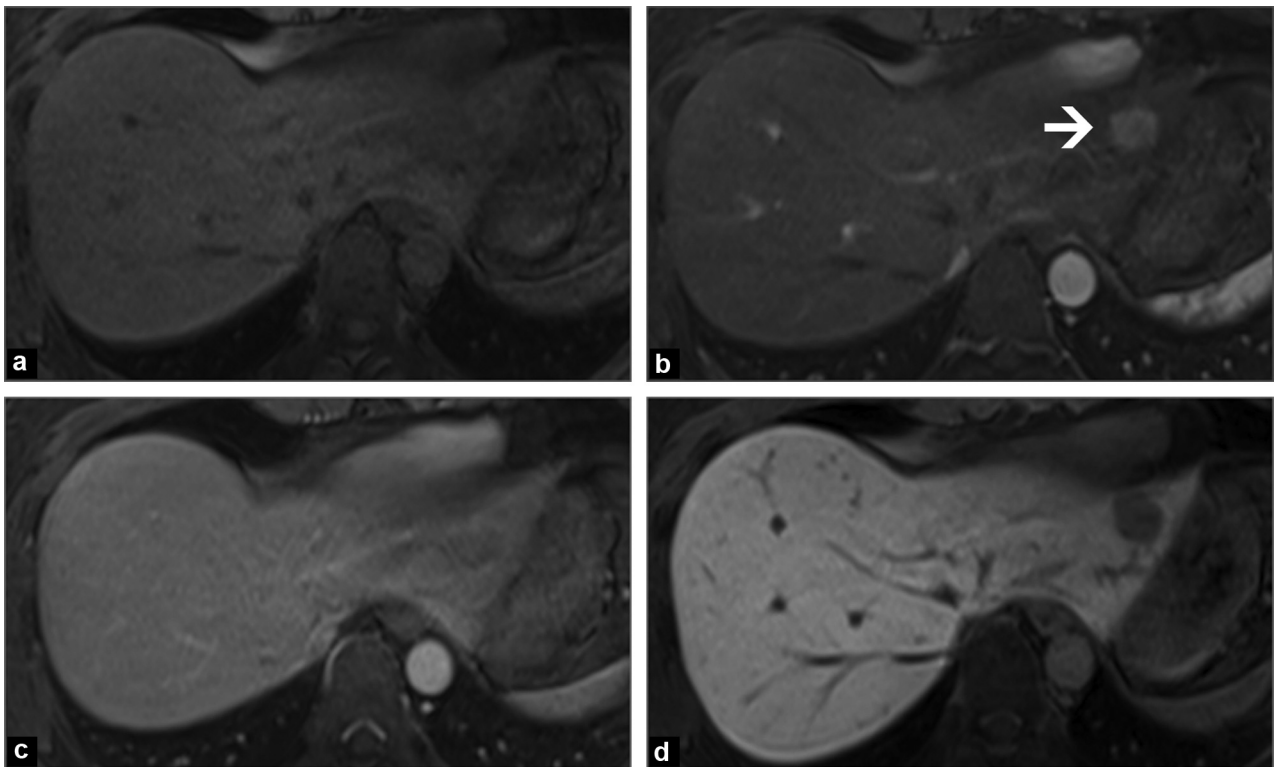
The usefulness of liver-specific contrast agents. T1-weighted MRI without (a) then after injection of gadoxetic acid in the arterial (b), portal (c) and hepatobiliary (d) phases. Hepatocellular carcinoma of the left lobe of the liver (arrow), enhanced in the arterial phase, without lesion washout and no fixation of the contrast agent in the hepatobiliary phase. Images from Myeon-Jin Kim (MD), Seoul, Republic of Korea.
